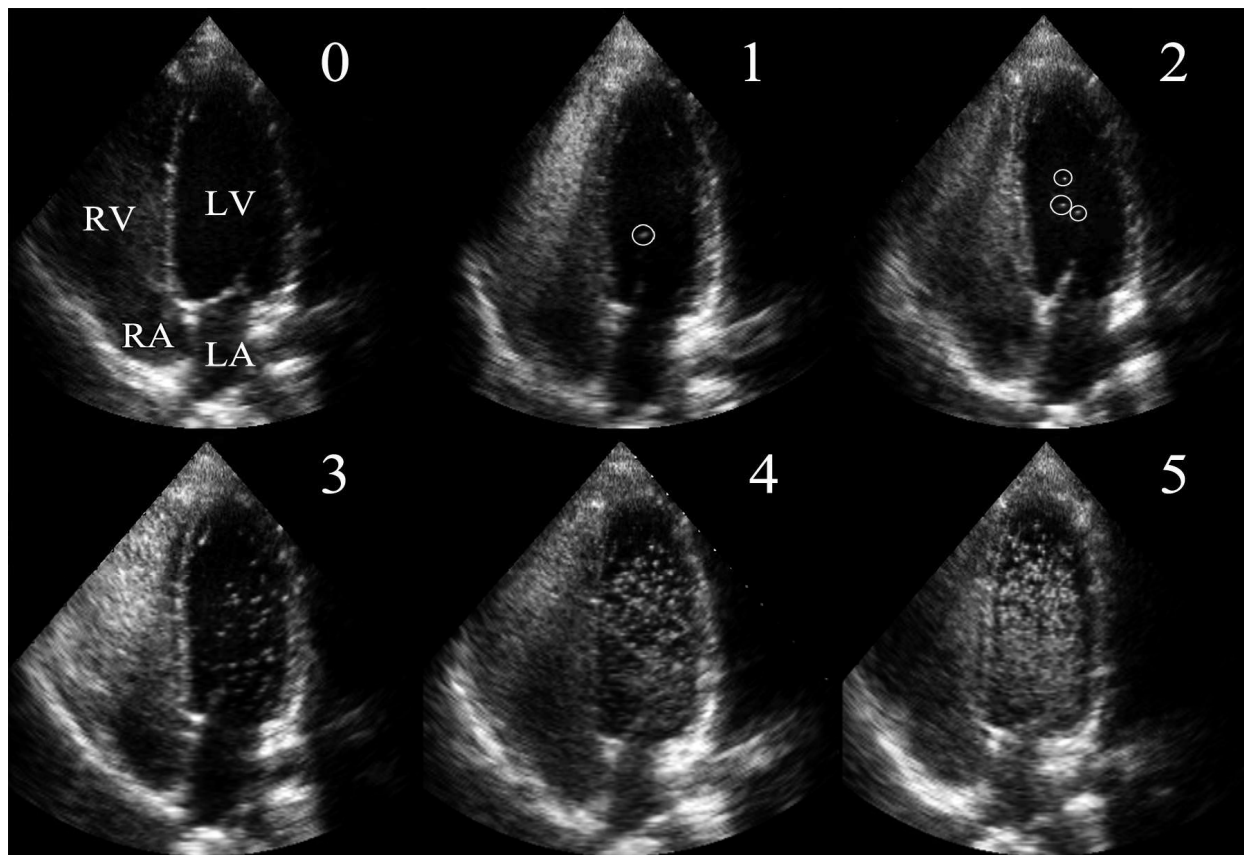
Representative echocardiograms of bubble scores. Scores are assigned based on both the density and spatial distribution of microbubbles in the left ventricle from the frame with the largest amount of contrast. A score of 0 = 0 microbubbles; 1 = 1 - 3 microbubbles; 2 = 4 - 12 microbubbles; 3 = more than 12 microbubbles in a bolus; 4 = more than 12 microbubbles heterogeneously distributed throughout the left ventricle; 5 = more than 12 microbubbles homogeneously distributed throughout the left ventricle. Scores 1 and 2 have bubbles circled for clarity. RA, LA = right & left atrium; RV, LV = right & left ventricle.
